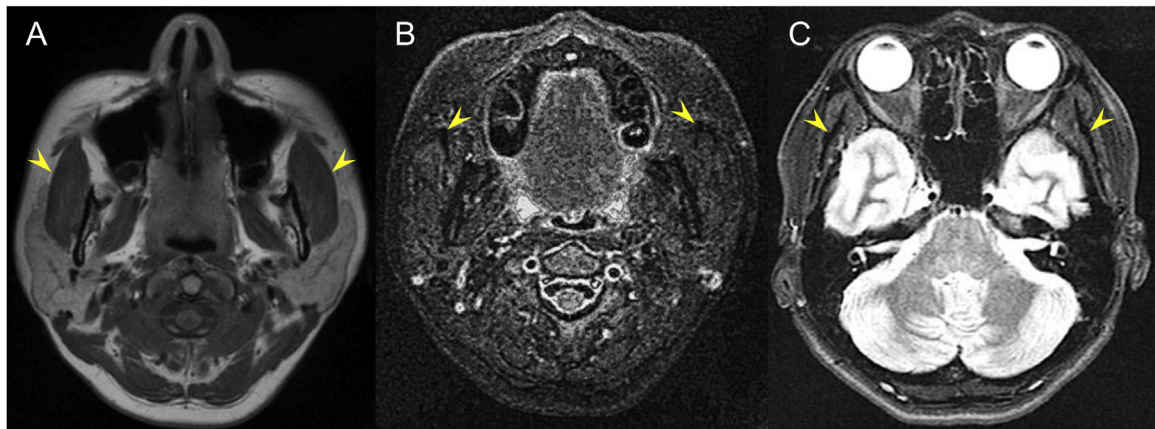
Pre-operative magnetic resonance imaging (MRI). (A) Axial T1-weighted image (T1WI). Arrowheads: enlarged masseter muscles. (B and C) Axial short TI inversion recovery (STIR) view. Arrowheads: bilateral masseter muscle aponeurosis (B) and bilateral thickened temporalis muscle tendon (C).
